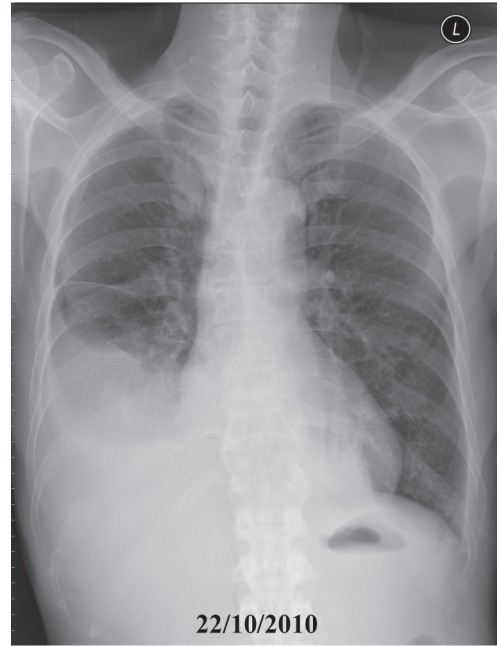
The chest x-ray shows progressive patchy infiltration with right pleural effusion.
